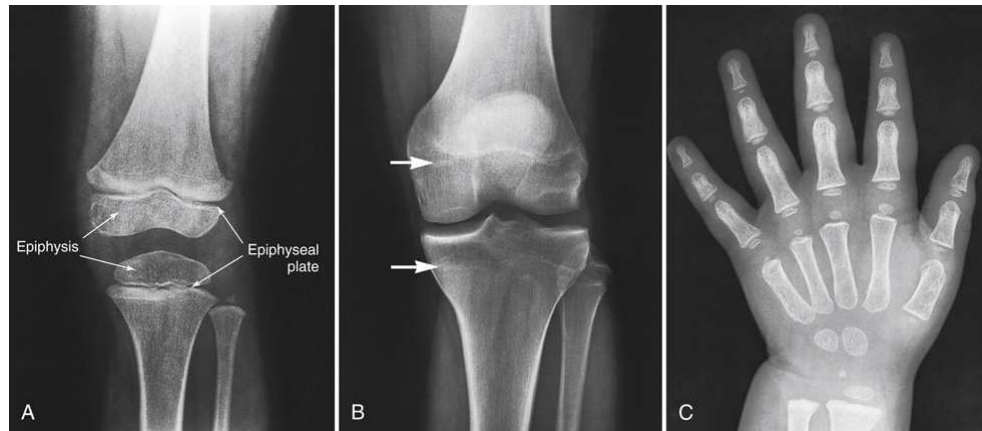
(A) Radiograph of a 6-year-old child. Epiphysis and epiphyseal plate shown on knee radiograph (*arrows*). (B) Radiograph of same area in a 21-year-old adult. Full ossification has occurred, and only subtle epiphyseal lines are seen (*arrows*). (C) PA radiograph of hand of a 2½-year-old child. Note early stages of ossification in epiphyses at proximal ends of phalanges and first metacarpal, distal ends of other metacarpals, and radius. C, From Standring S. *Gray's Anatomy*. 40th ed. New York: Churchill Livingstone; 2009.
